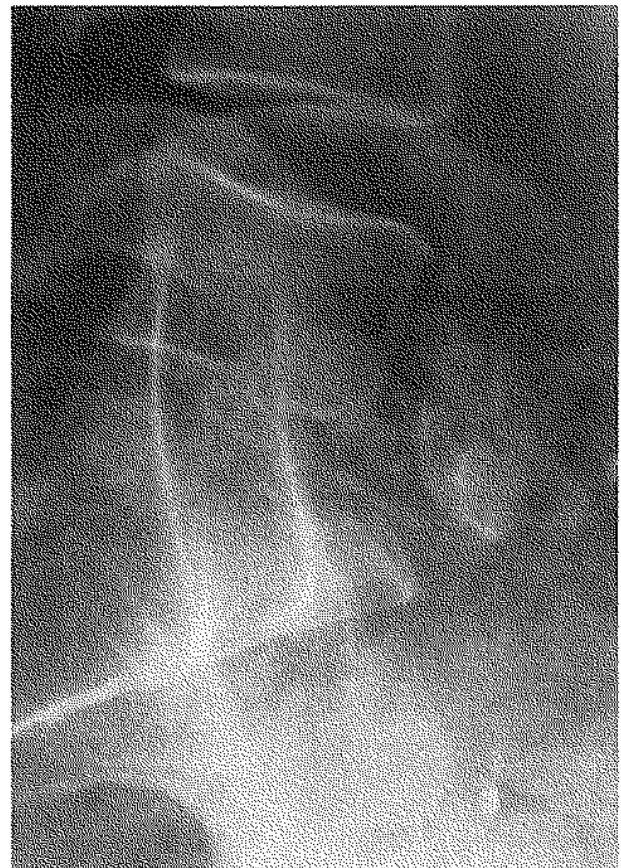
Lateral x-ray showing massive osteolysis of the 5th lumbar vertebra and its collapse into the vertebral space.
